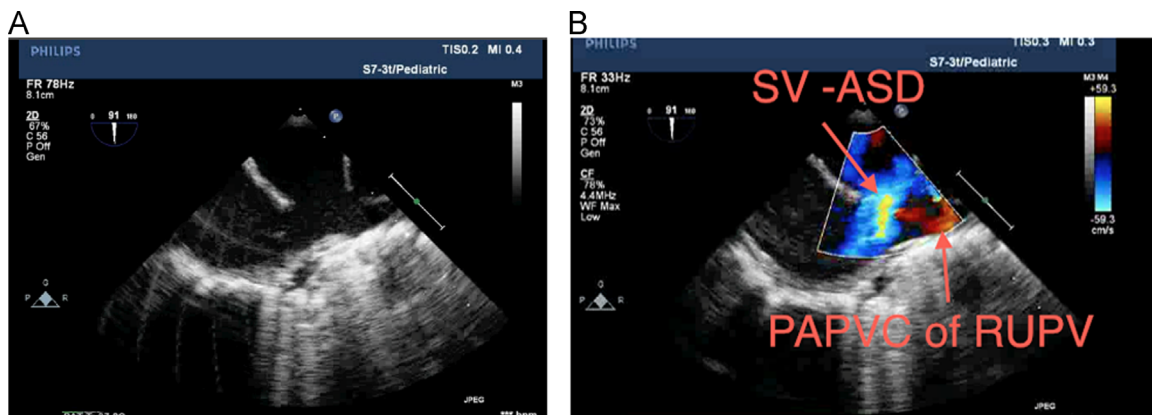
(A) Midesophageal bicaval view shows sinus venosus atrial septal defect (SV-ASD). (B) Midesophageal bicaval view with color-flow Doppler showing SV-ASD with left-to-right shunt and the right upper pulmonary vein draining into the superior vena cava at a 2-cm proximity to the superior vena cava and right atrium junction. Abbreviations: SV-ASD, sinus venosus atrial septal defect; PAPVC, pulmonary venous connection; RUPV, right upper pulmonary vein.
